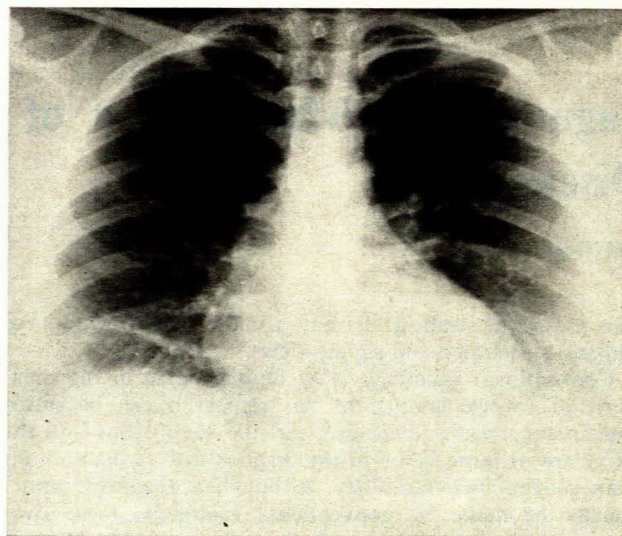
The importance of distance and position on the apparent heart size in an adult can be seen. Top: antero-posterior radiograph done at 1 metre and the heart shadow appears to be considerably enlarged; bottom: postero-anterior radiograph done at 2 metres and the heart shadow is within normal limits.
